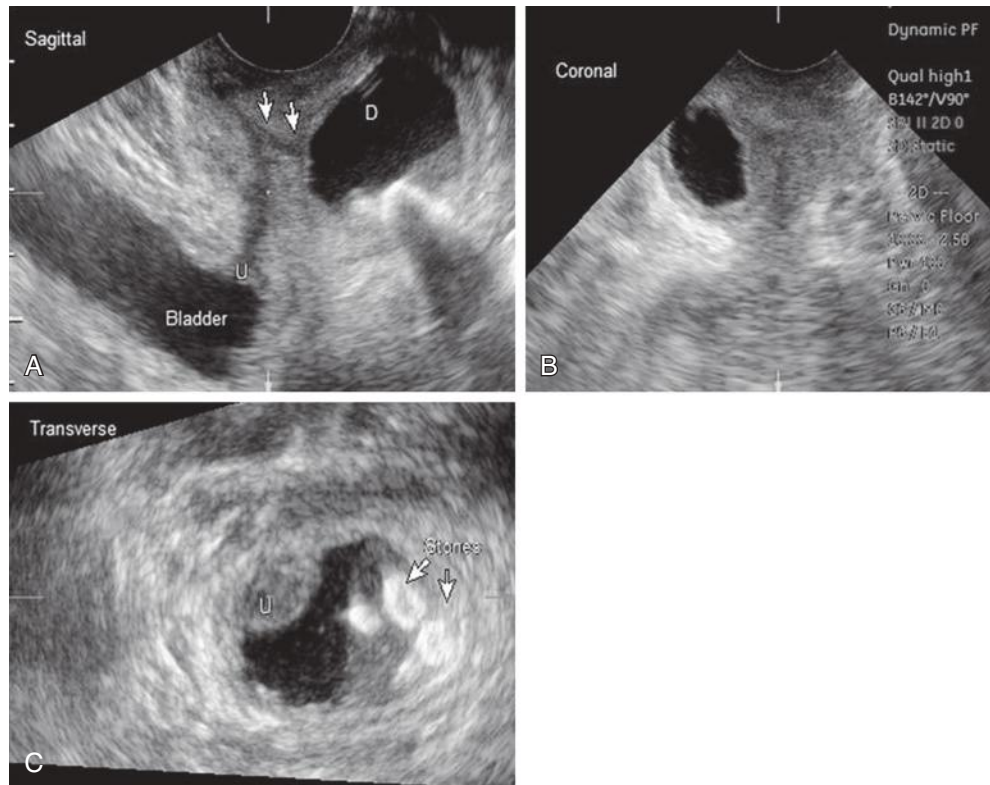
Urethral diverticulum on ultrasound imaging showing sagittal (A), coronal (B), and transverse (C) planes. Multiplanar ultrasound images showing a large diverticulum (D) with multiple echogenic stones (arrows in transverse image) and dependent layering debris. Urethra (u) and fluid-filled anechoic bladder are seen. The hypoechoic diverticular tract is also well visualized on the sagittal image (arrows).
